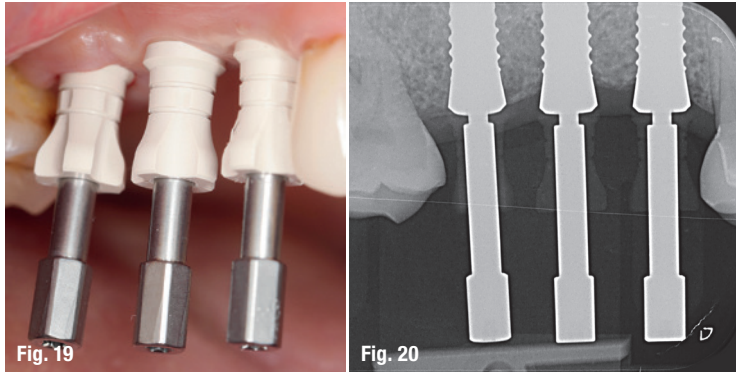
Lateral view of impression posts. Fig. 20: Radiographic control image.
